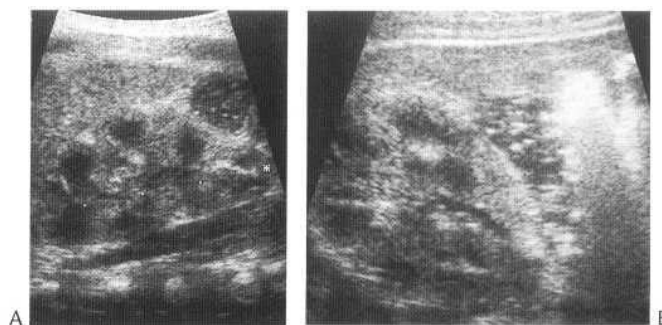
Renal ultrasound. Coronal (A) and transverse (B) images of a neonatal kidney demonstrating prominent hypoechoic medullary pyramids and no renal sinus fat.
